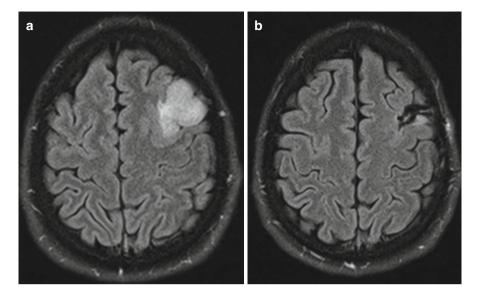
T2-weighted MRI before (a) and 1 year after the operation (b) of a low-grade glioma. In the follow-up image, the craniotomy site and some degree of gliosis are to be seen
